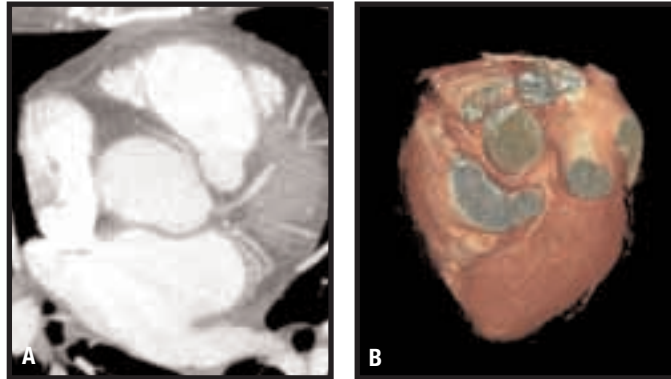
52-year old woman who presented to the emergency department with sudden-onset chest pain. Coronary CTA revealed a malignant anomalous right coronary artery, arising in the ascending aorta posterior to the pulmonary outflow tract, and coursing between the pulmonary outflow tract and ascending aorta, as shown on maximum-intensity projection (A) and surface rendered view (B).
